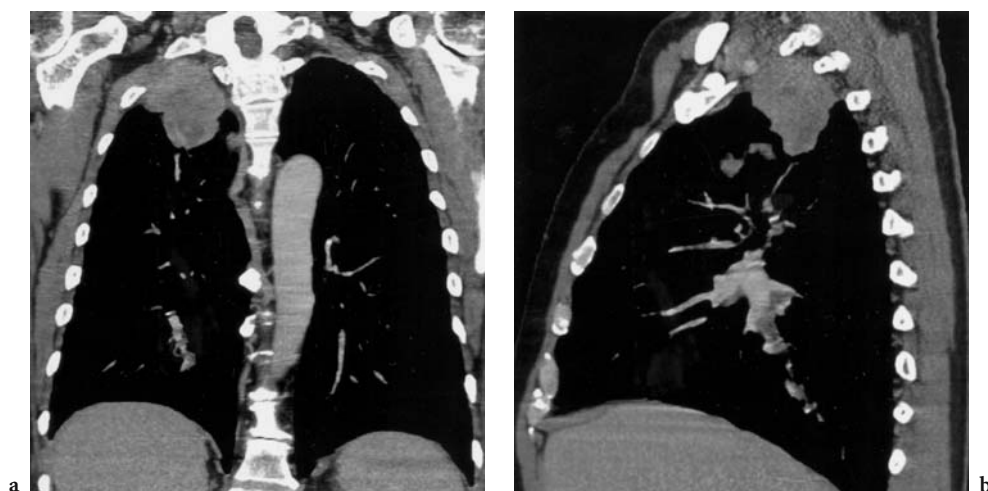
Apical lung tumor. Coronal (a) and sagittal (b) multiplanar reformation CT images demonstrate a right apical lung mass. The reformation images showed the extent of tumor to greater detail than axial images (not shown). Although MR is the study of choice for superior sulcus tumors, MDCT with multiplanar reformation images is a reasonable alternative for patients with contraindications to MR
